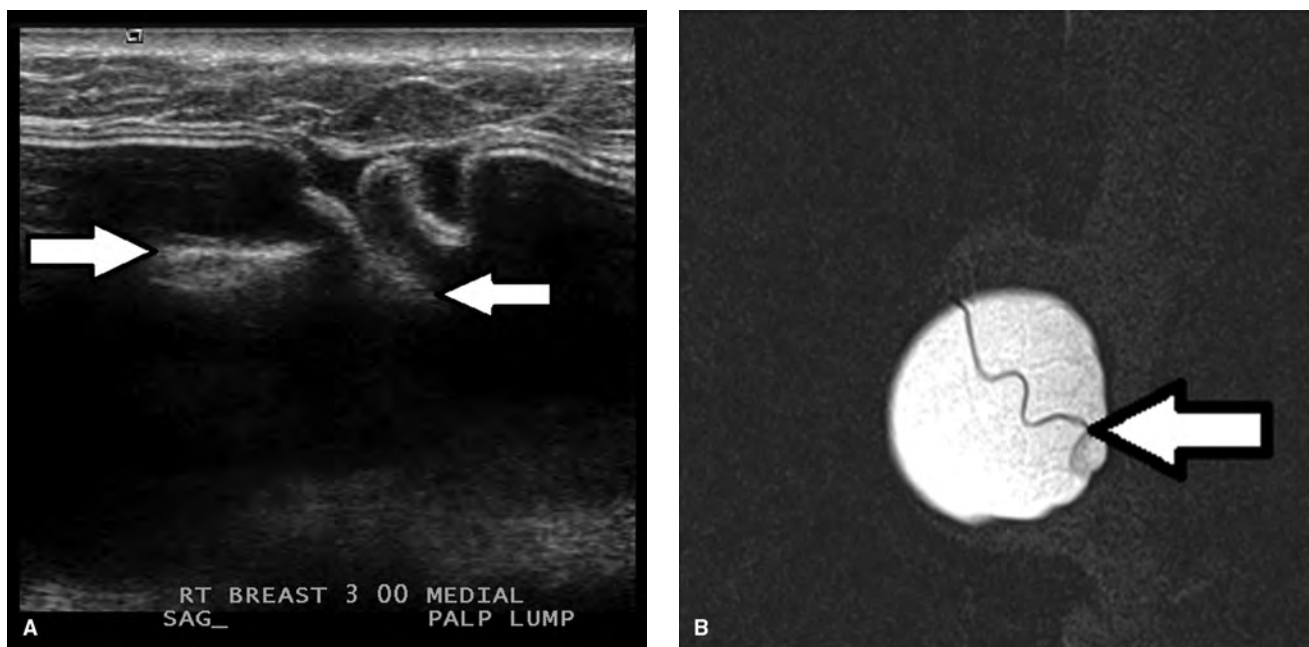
(A) “Stepladder sign” of intracapsular silicone implant rupture (*arrows*). (B) Corresponding “linguini sign” seen on breast MRI (*arrow*).
